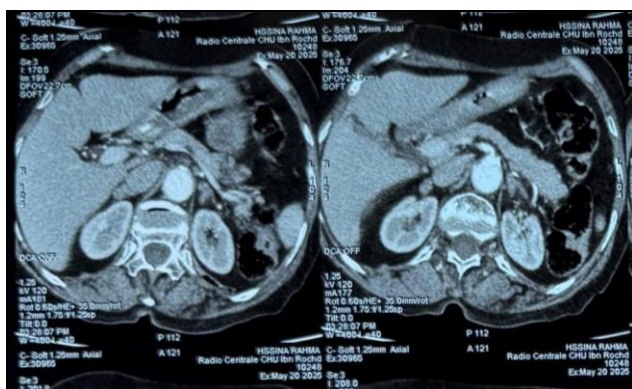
CT scan (May 20, 2025) demonstrating a heterogeneous fundal mass
